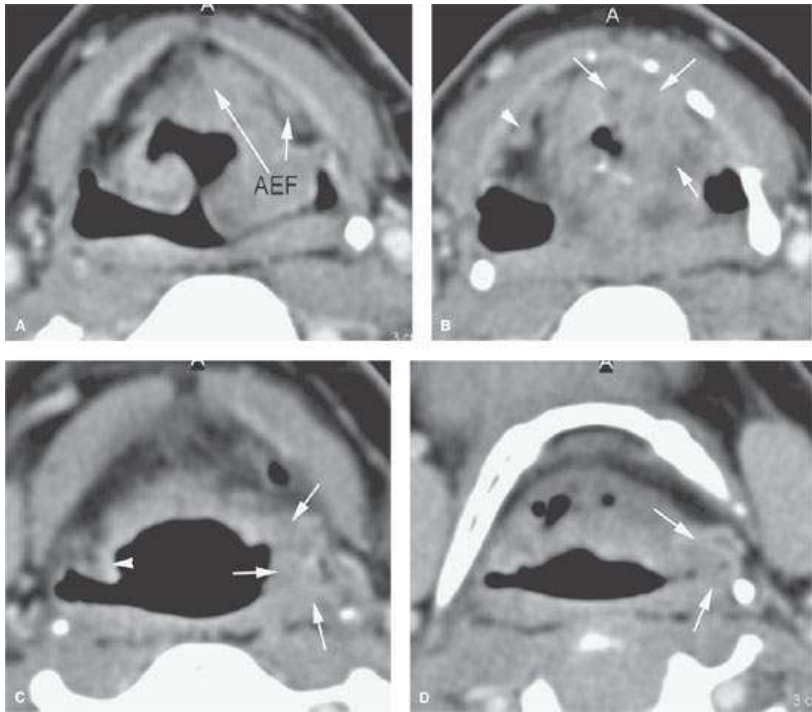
Typical relatively low volume marginal supraglottic lesion as seen on contrast-enhanced computed tomography. A: This is a primary lesion of the aryepiglottic fold (AEF) spreading from the fold to the pre-epiglottic space and paraglottic space (arrows). B: A section inferior to that seen in (A) showing widespread infiltration of the paraglottic space and low pre-epiglottic space (arrows) compared to the normal side (arrowhead). C: More superior sections showing tumor spreading up the aryepiglottic fold (arrows), thickening the fold compared to the normal side (arrowhead). D: Relatively low volume exophytic tumor spreading superiorly to the junction of the aryepiglottic fold and pharyngoepiglottic fold (arrows). (NOTE: This was a relatively low volume supraglottic carcinoma, being just under 6 cc. It was successfully treated with radiotherapy.)
